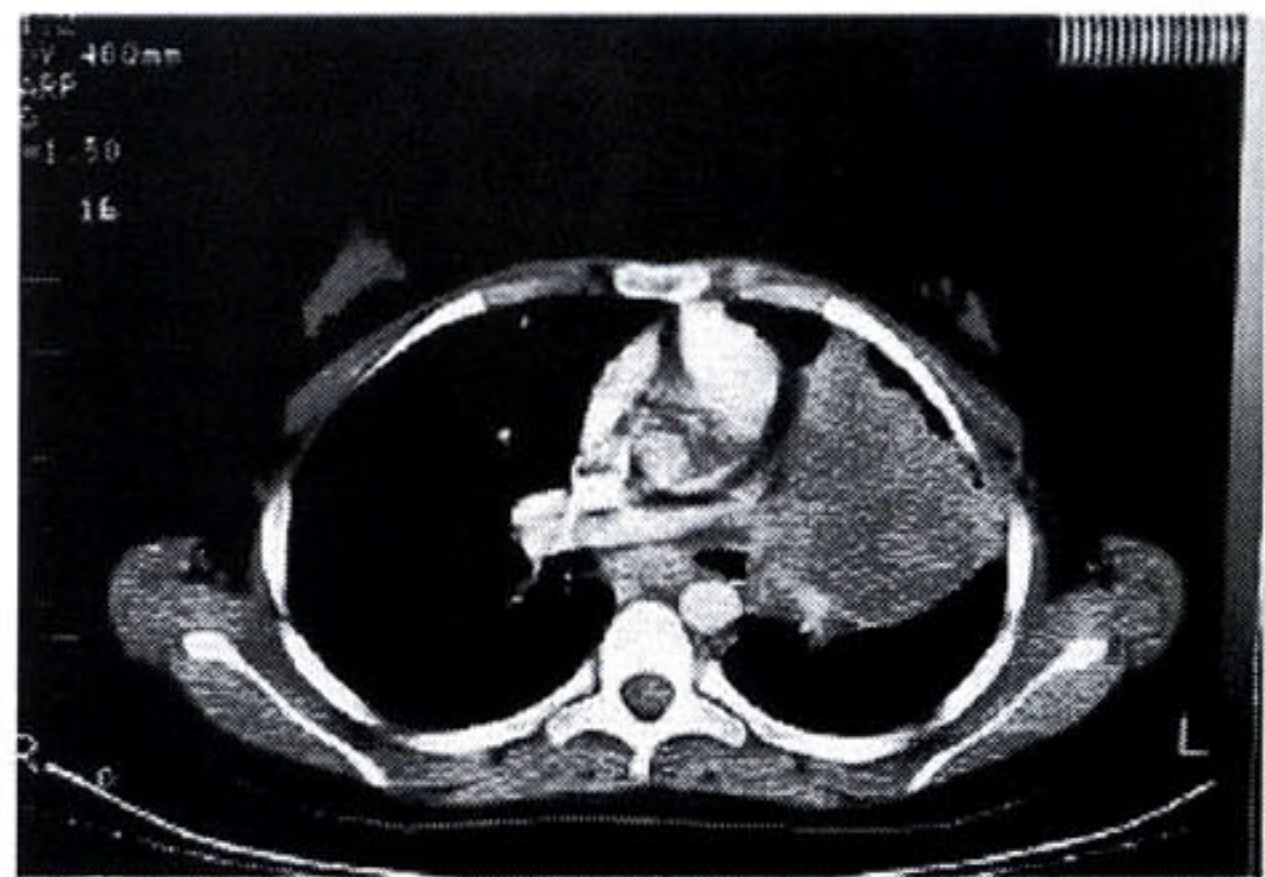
Chest Computed Tomography Scan shows a left upper lobe mass with increase areas of necrosis and encasement of the left hilum.
